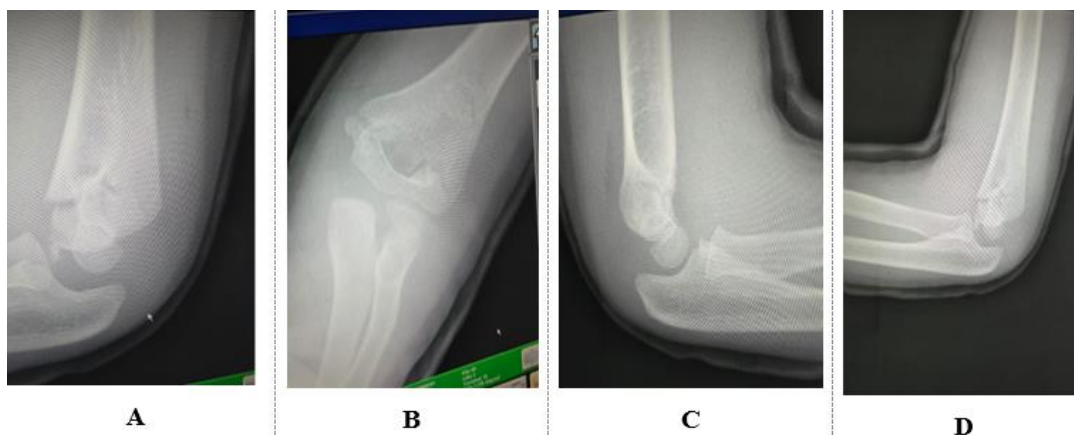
Post-Reduction Radiographs Showing Successful Closed Reduction and Alignment of Fracture Fragments with High Above-Elbow Cast Immobilization
